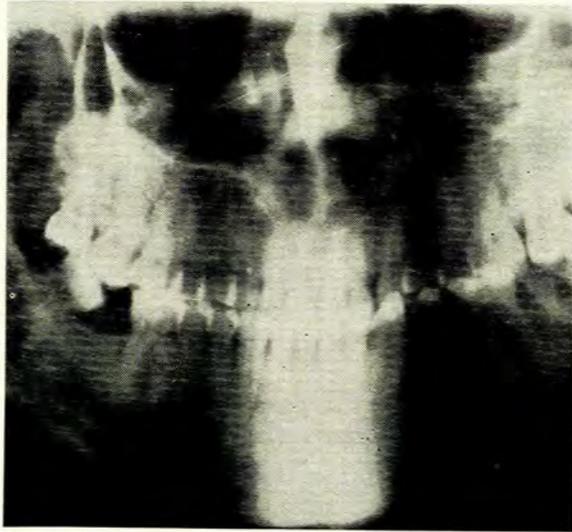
Orthopantomograph of maxilla in case 4, showing a median palatine cyst.
